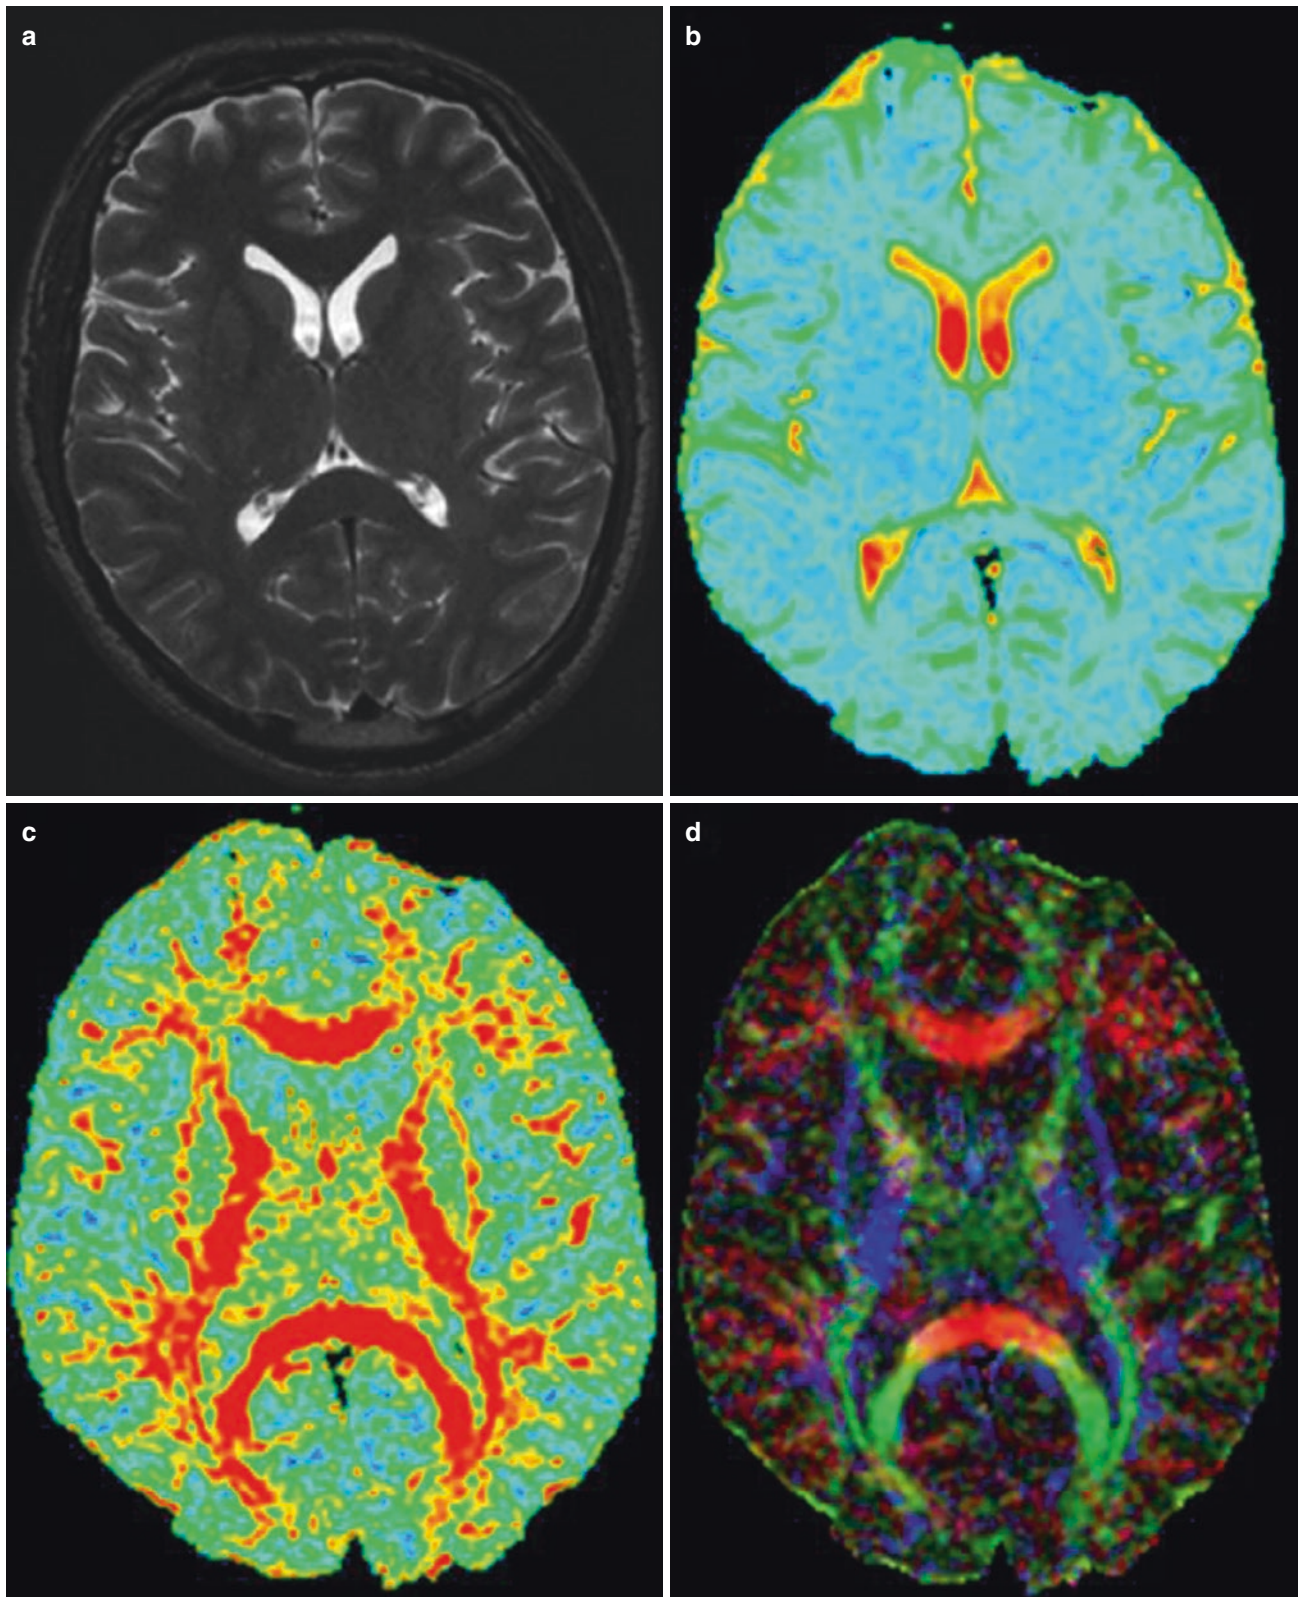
(a) T2-weighted image; (b) Average DC; (c) FA map; (d) Color-coded orientation map. Images were acquired using a 3.0 T scanner. The colors (red, green, blue) correspond to different orientations of fibers; red: right-left, green: anterior-posterior, and blue: superior-inferior
